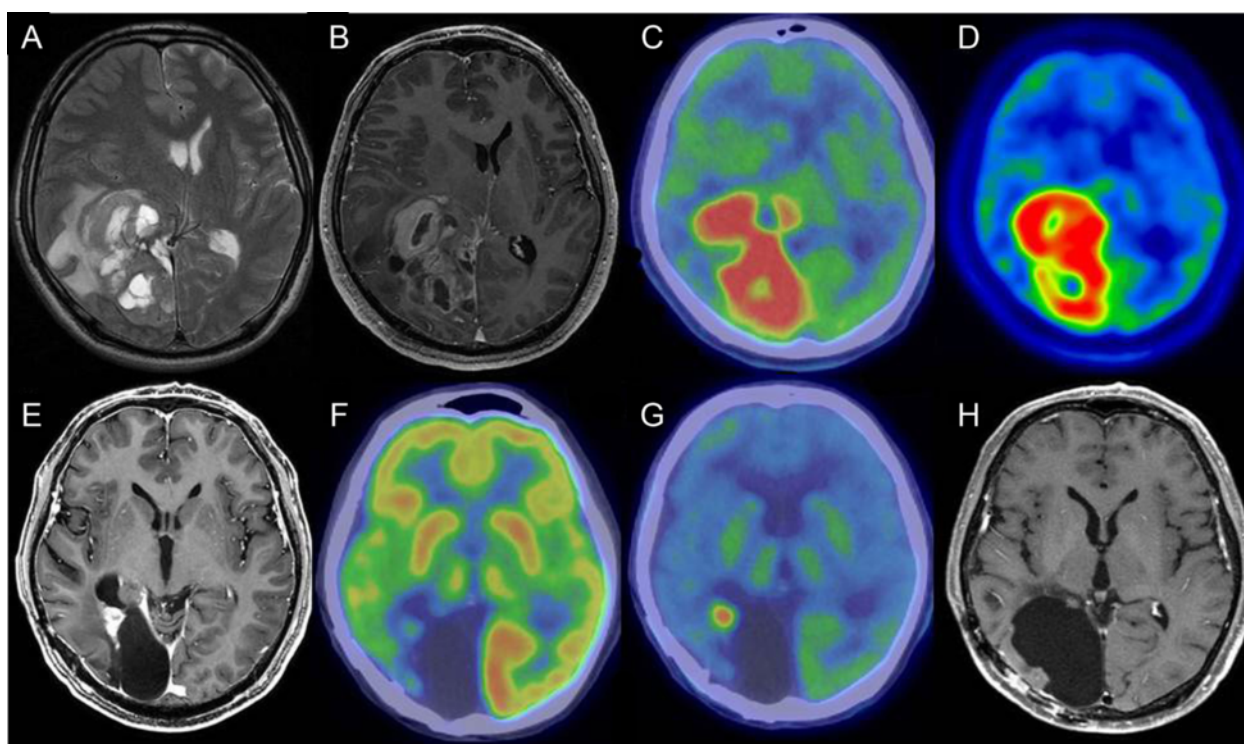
Magnetic resonance imaging (MRI) and positron emission tomography (PET). (A) T2-weighted image showing a huge multicystic mass in the right occipitoparietal area with marked surrounding edema and shift of the midline structures to the left side. (B) Each cyst wall and adjacent cortical mass was enhanced with contrast medium. (C) Fluorodeoxyglucose (FDG) PET showing high accumulation in the right occipitoparietal area. (D) Methionine (MET) PET showing high accumulation in the right occipitoparietal area. (E, F) MRI and PET findings at the time of recurrence. (E) Small enhanced mass adjacent to the cavity formed by removal of the tumor. (F) FDG-PET showing no accumulation in the mass. (G) MET-PET showing high accumulation in the mass. (H) MRI 4 years after the first operation.
